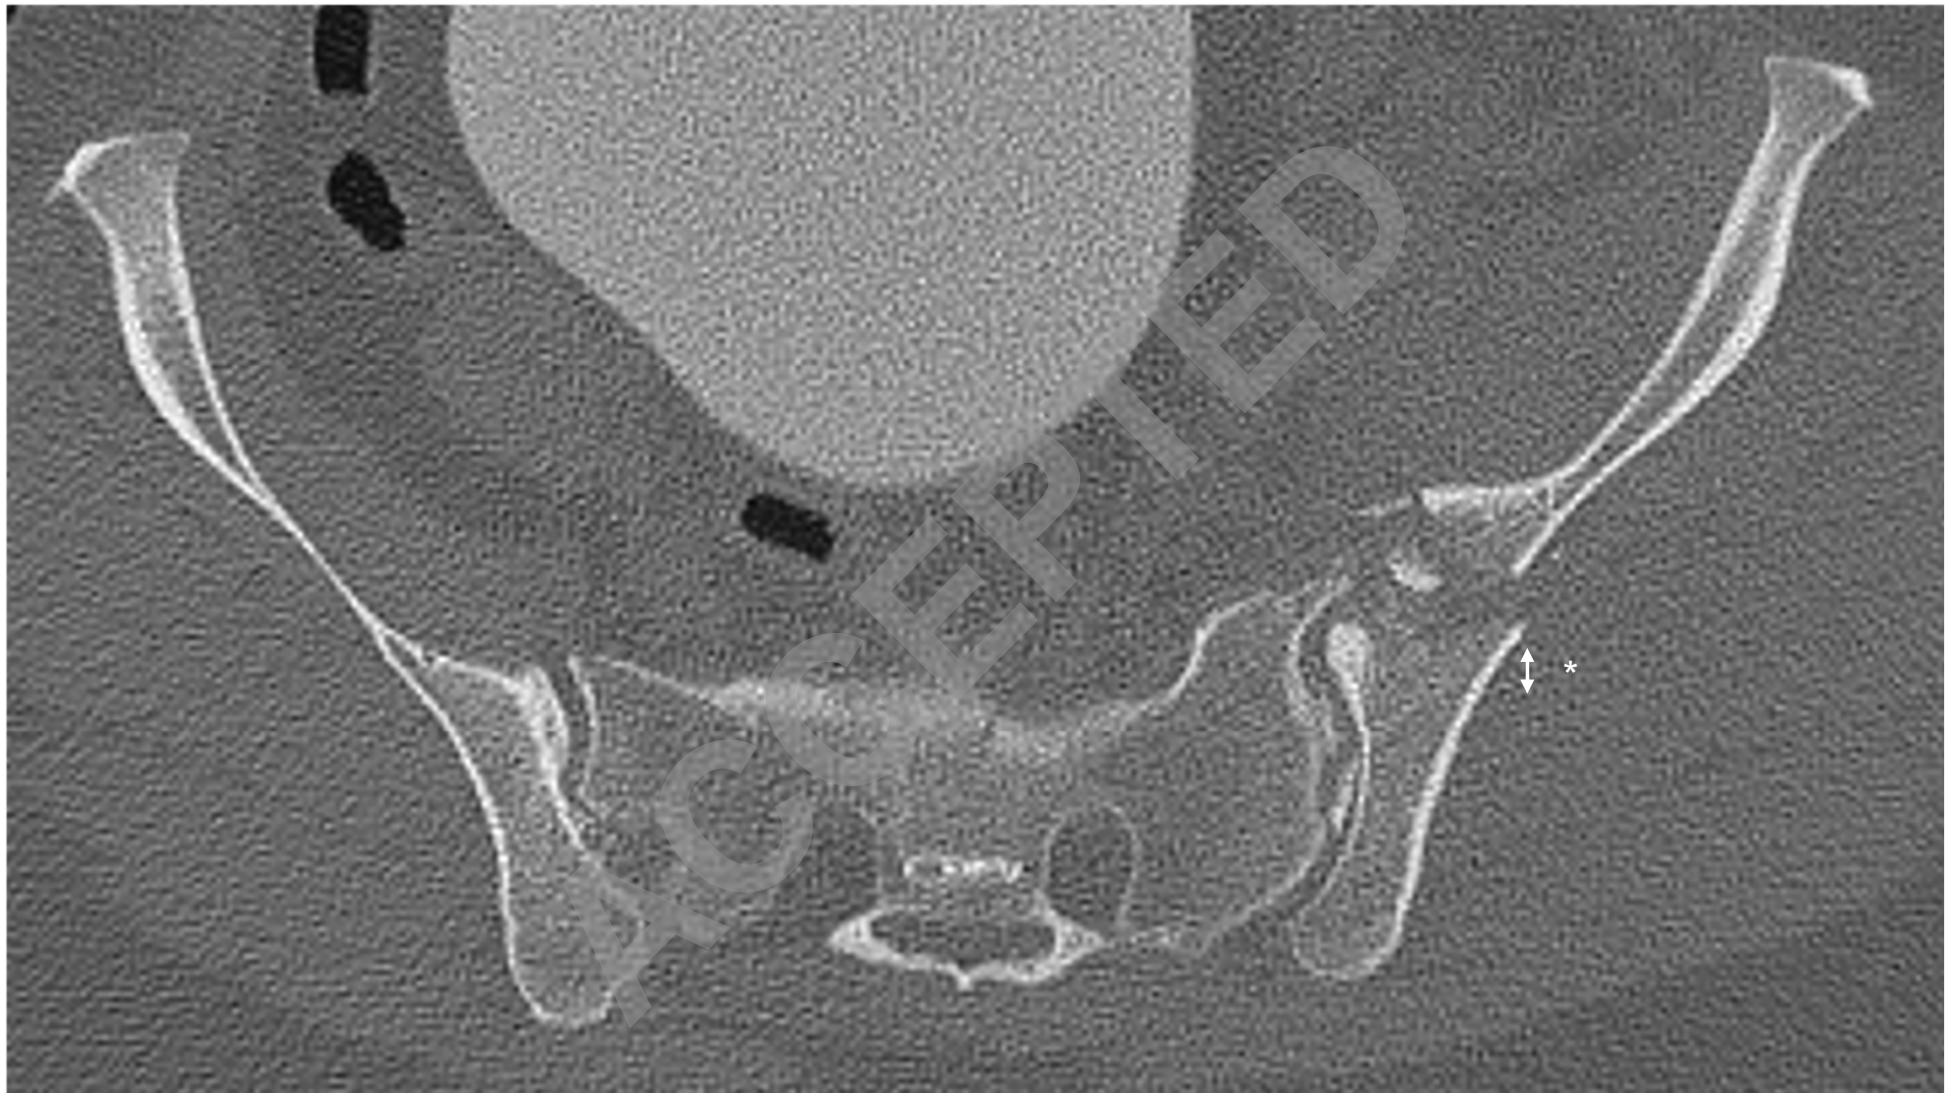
Initial crescent fracture displacement (CFD) was measured between the posterior cortices of the crescent fragment and iliac fragment at the point of maximal displacement on axial CT cuts (asterisk).
